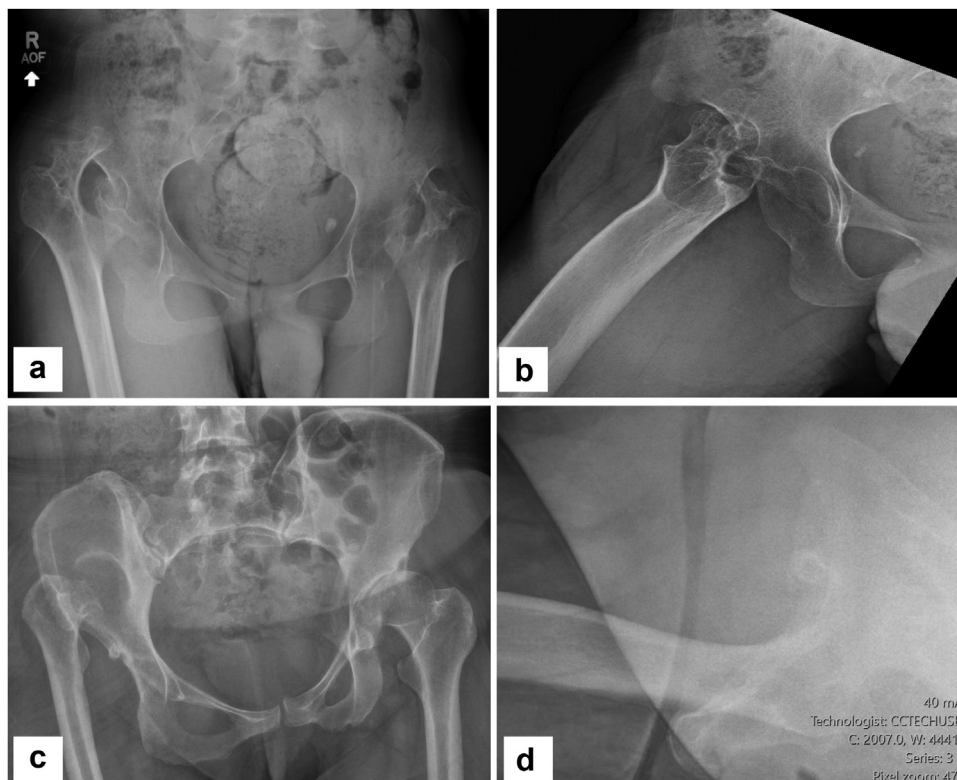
Preoperative (a) anteroposterior pelvis and (b) frog-leg lateral radiograph of the right hip from example patient #1. Preoperative (c) anteroposterior pelvis and (d) cross-table lateral radiograph of the right hip from example patient #2.
